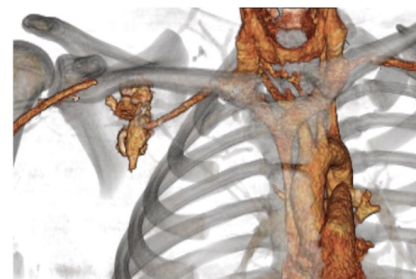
Active spreading of contrast from the right subclavian artery in arterial phase contrast CT scan, suggesting traumatic rupture in addition to type VI right AC dislocation.
